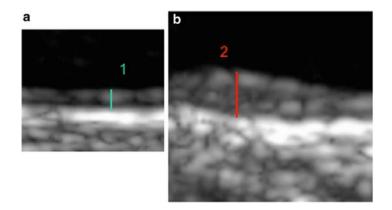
(a) Ultrasonographic morphology of the normal arterial wall with quantification of the intima-media thickness (IMT). (b) Increased IMT with destruction of the normal artery morphology
